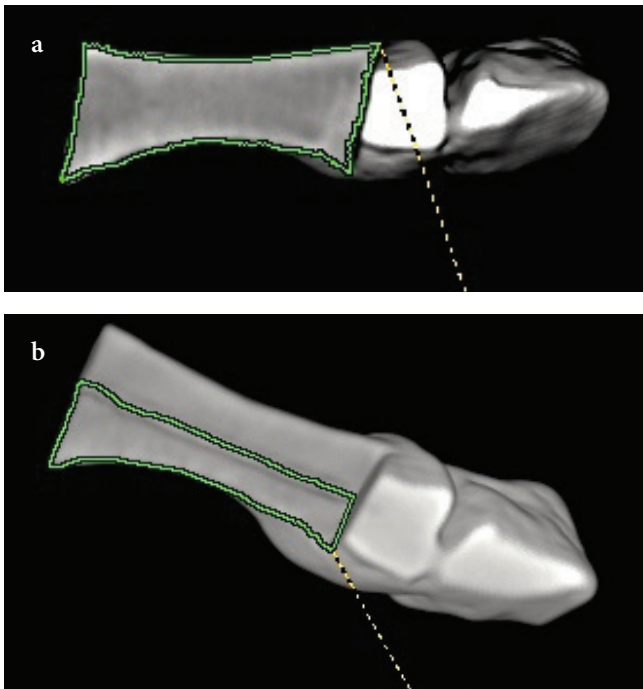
a, b. Pre- and post-correction osteotomy-site contact surface area 3D CT scan measurement of scarf osteotomy
